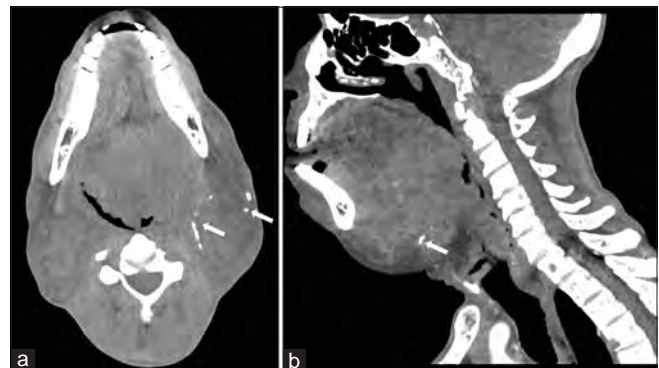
(a) Axial and (b) sagittal computed tomography scan of the neck showing a huge ill-defined heterogeneous predominantly isodense mass in the bilateral submandibular region more to the left and extends superiorly to the floor of the mouth. Curvilinear calcifications are noted (arrows)
